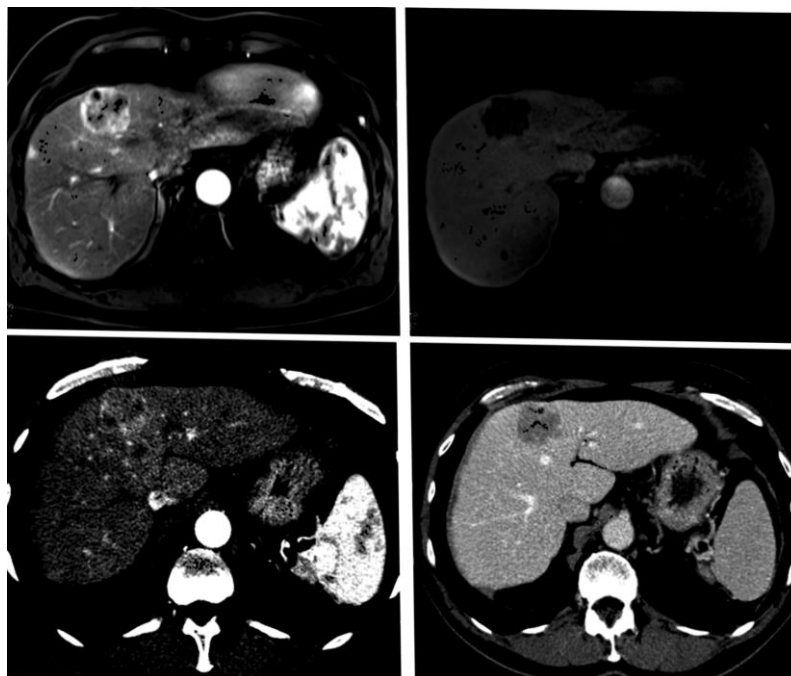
Top row: Post Gadolinium T1 weighted MRI image (top left) showing arterially hyperenhancing early-HCC with washout (top right) Bottom row: Arterial phase contrast CT of same patient taken 1 week later showing the hyperenhancing early-HCC (bottom left) with washout on portal venous phase (bottom right). Note that the arterial hyperenhancement of the lesion is much more conspicuous on the contrast MRI (CE-MRI) than on contrast CT (CECT).
